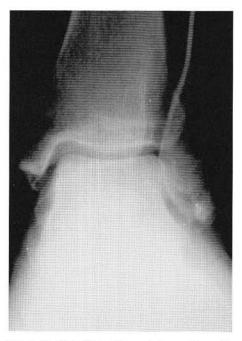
Plain-film radiograph in a patient with chronic ankle pain and a history of injury.
